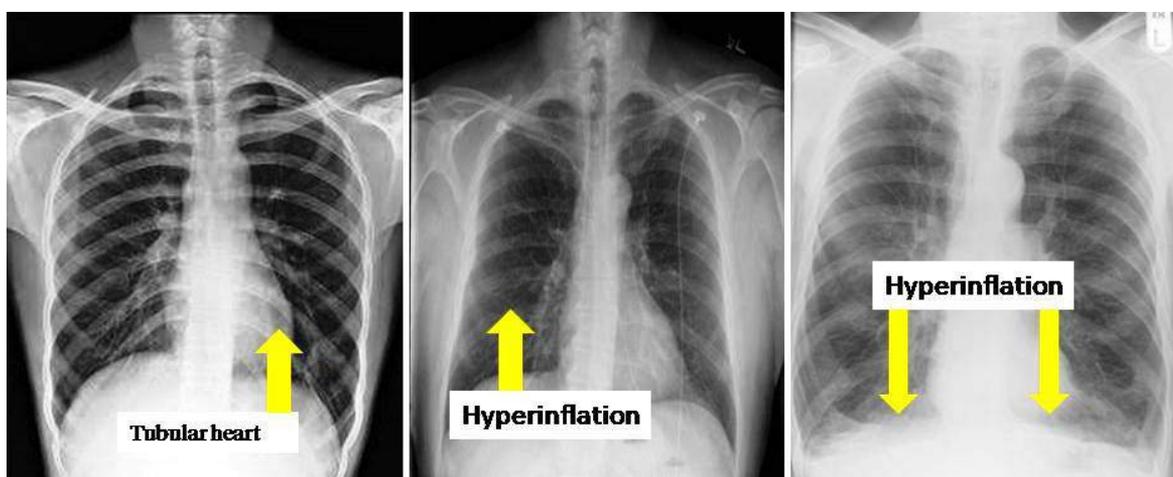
Chest X-ray of Non smoker COPD patients
